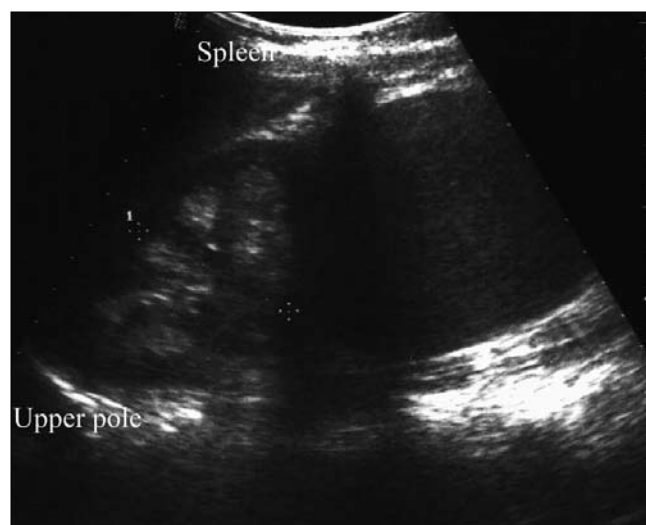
Ultrasound image of the tumor showing its relation to the surrounding organs and left kidney.
